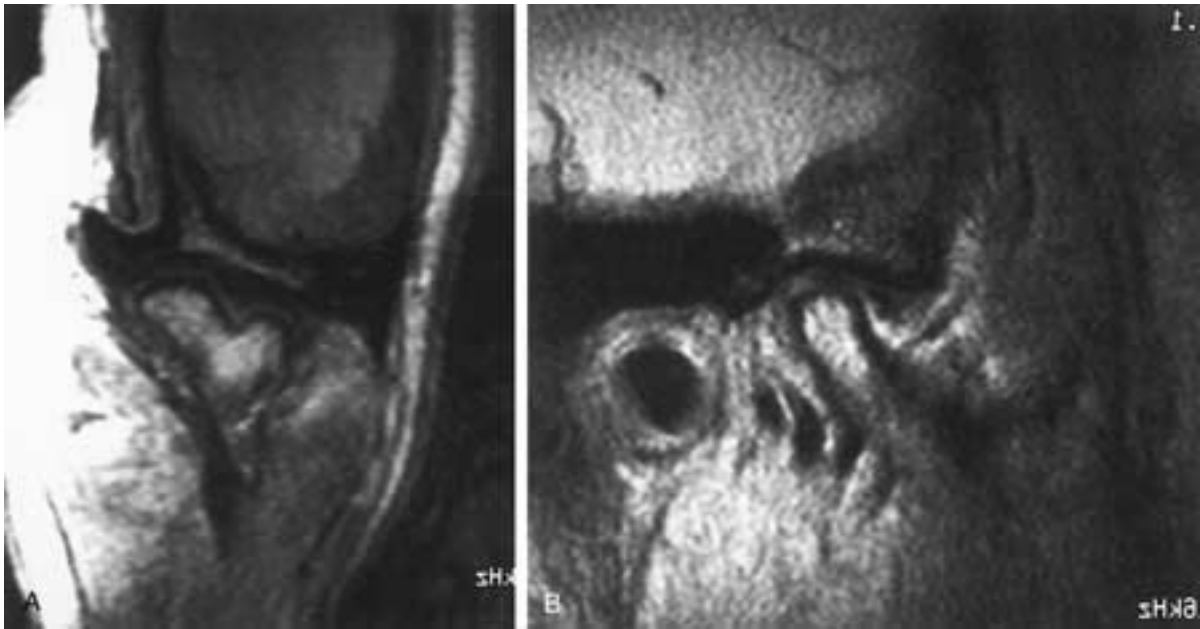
Bifid condyle. A, Coronal MR image shows the characteristic appearance of a bifid condyle. B, Sagittal MR image shows a normal appearance of the condyle and disk.
